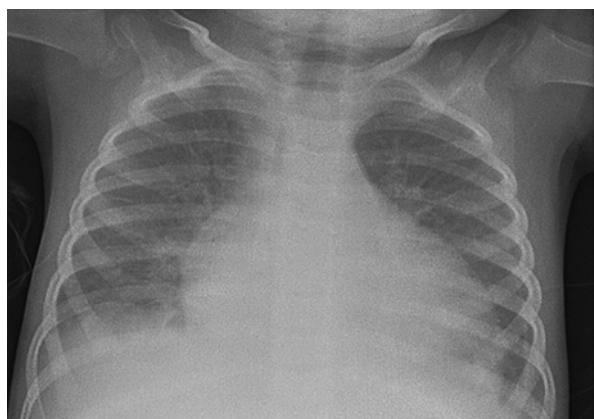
Chest x-ray at presentation showing enlarged heart and pulmonary oedema
